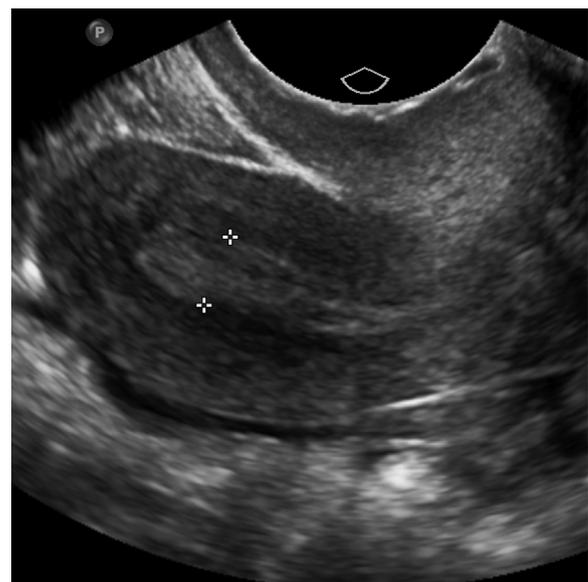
A 66-year-old woman with postmenopausal bleeding. Transvaginal sagittal ultrasound shows thickened heterogeneous endometrium measuring 6 mm (calipers; abnormal 5 mm or greater). There was mild colour flow (not shown). Endometrial biopsy revealed a benign polyp.
